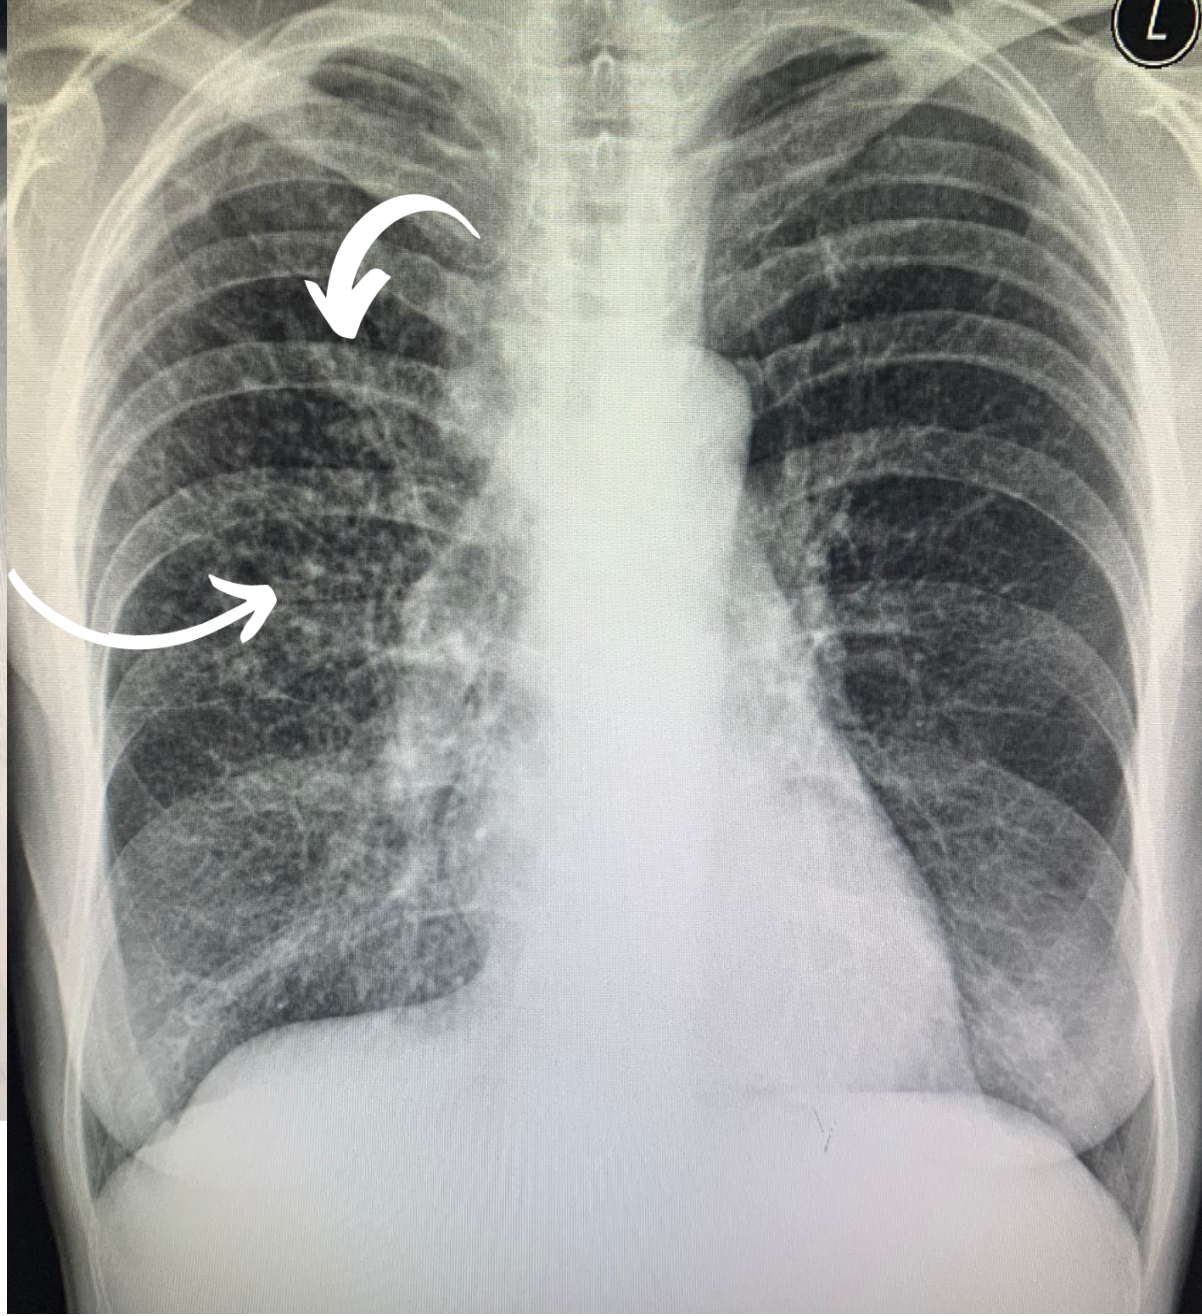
Chest X-ray of atypical radiological changes
